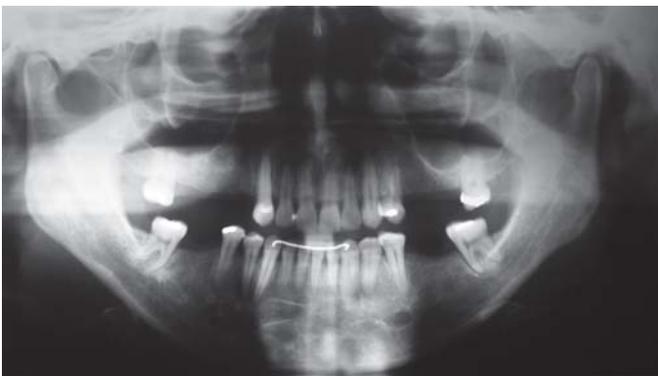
Post-treatment radiograph
